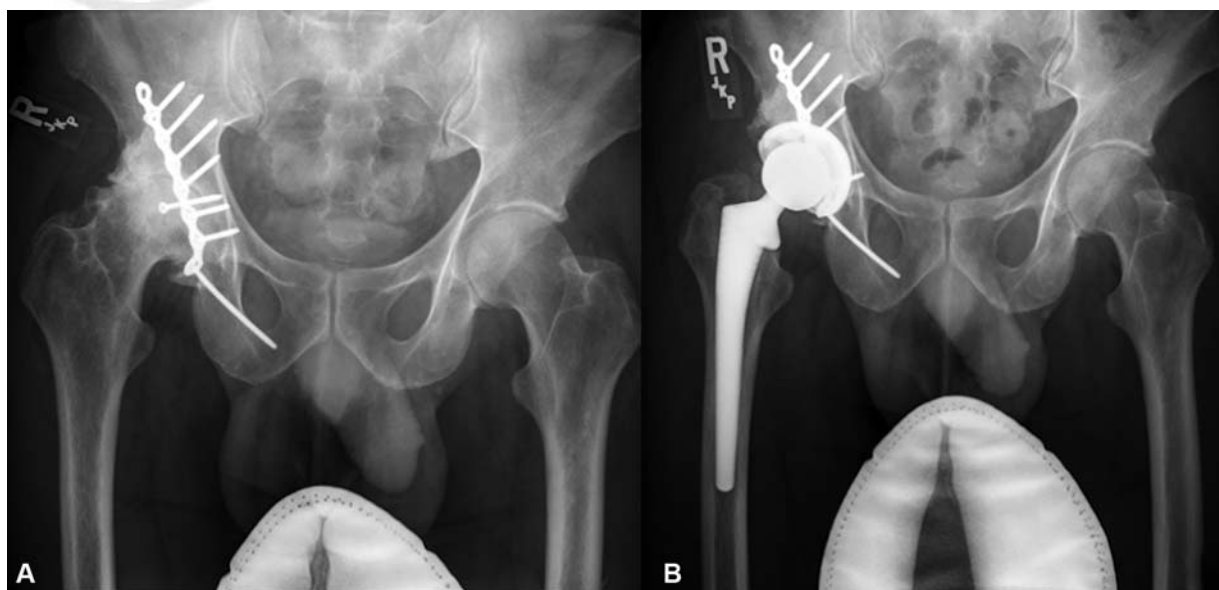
Radiographs of a THA after ORIF of posterior wall and posterior column fractures. (A) Preoperative radiograph of the right hip shows posterior plating and post-traumatic arthritis. (B) Posterior plate is retained around a THA. A middle screw in the plate and the posterior wall fixation screw were removed through the acetabulum. ORIF, open reduction internal fixation; THA, total hip arthroplasty.
